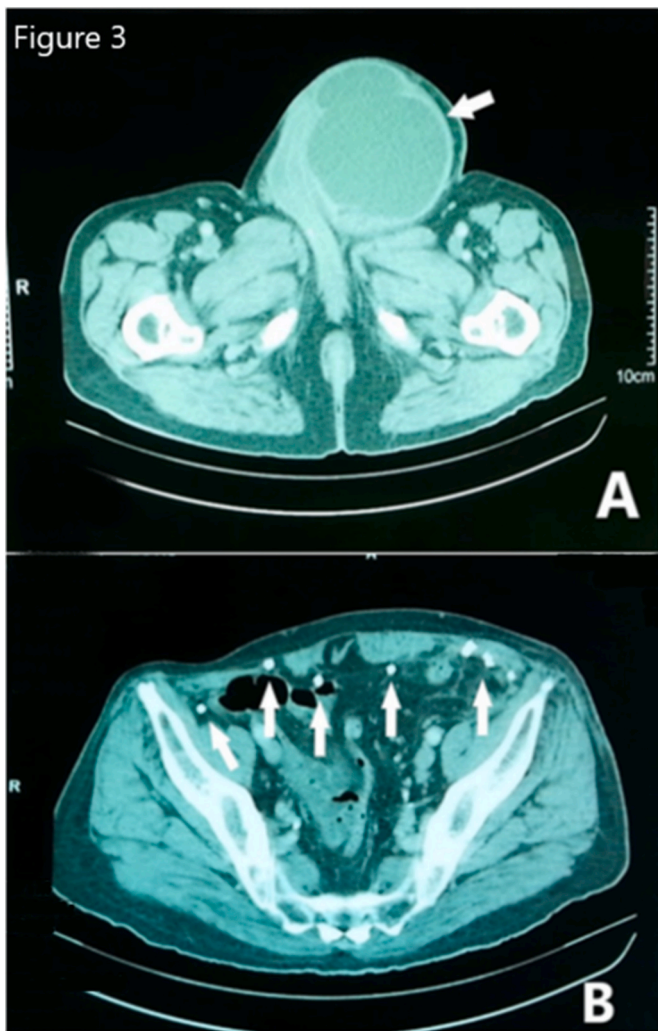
Abdomen and pelvic CT scan showing: A) a large abscess on the left hemiscrotum (arrow) B) the tackers used for the mesh fixation of the bilateral inguinal hernia (arrows).
